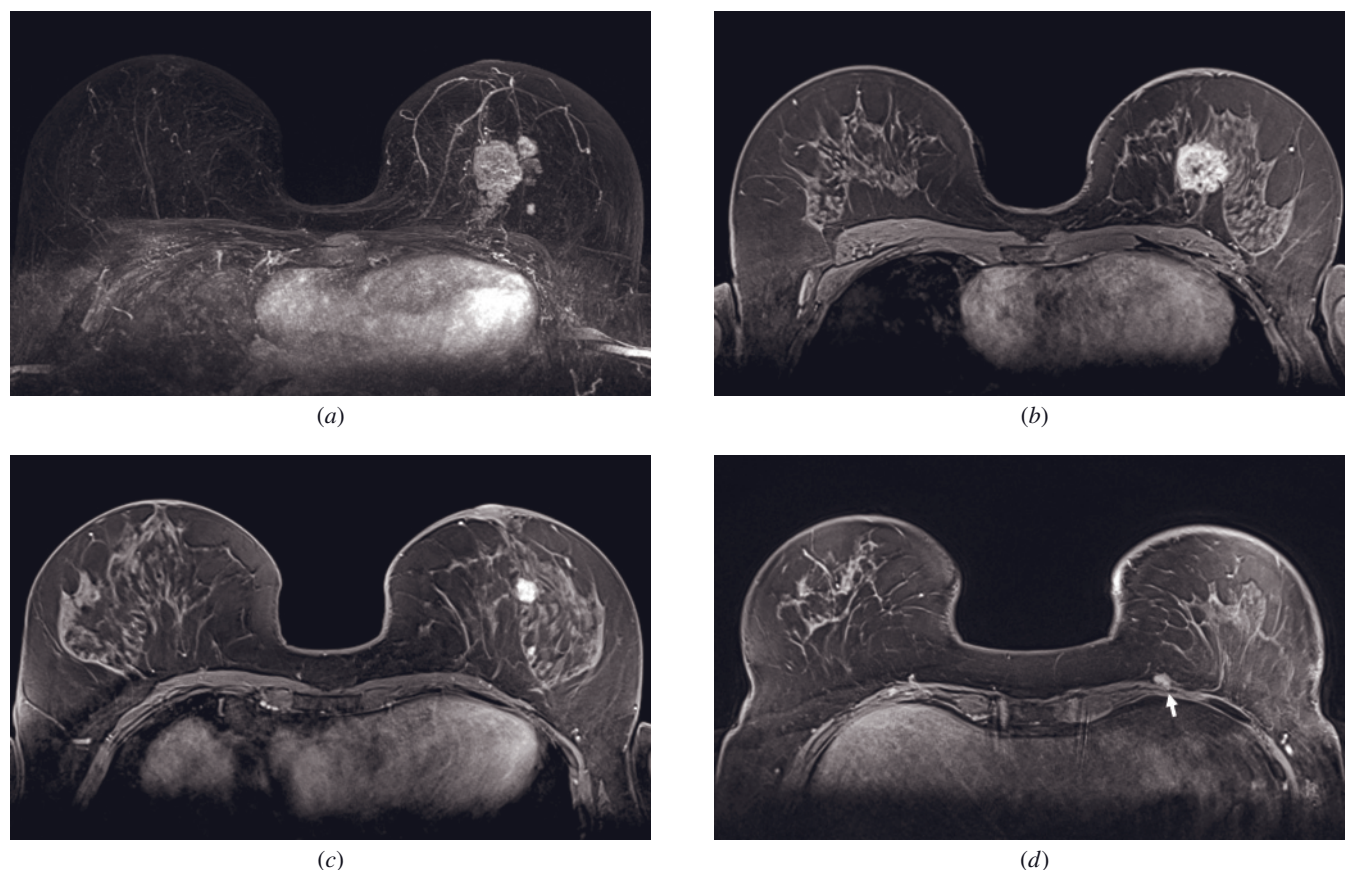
Multicentric IDC at postoperative MRI. Multicentric IDC is shown at preoperative MRI exam on the MIP image (a) in the left breast. Postcontrast GRE images (b, c) show typical morphology of invasive cancers and obvious invasion of the pectoral muscle (arrow, d), influencing surgical approach.
